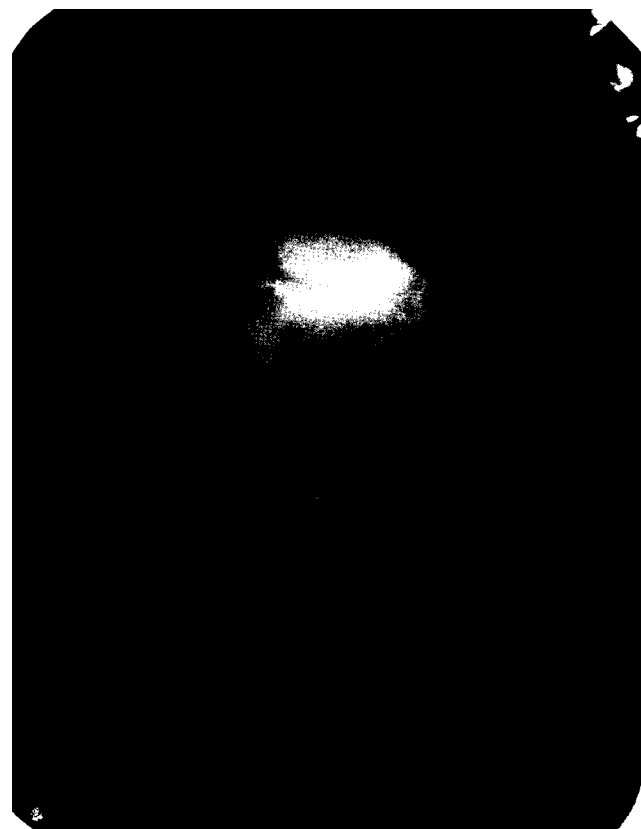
Radiograph of extracted tooth showing enlarged pulp chamber with absence of root canals.
